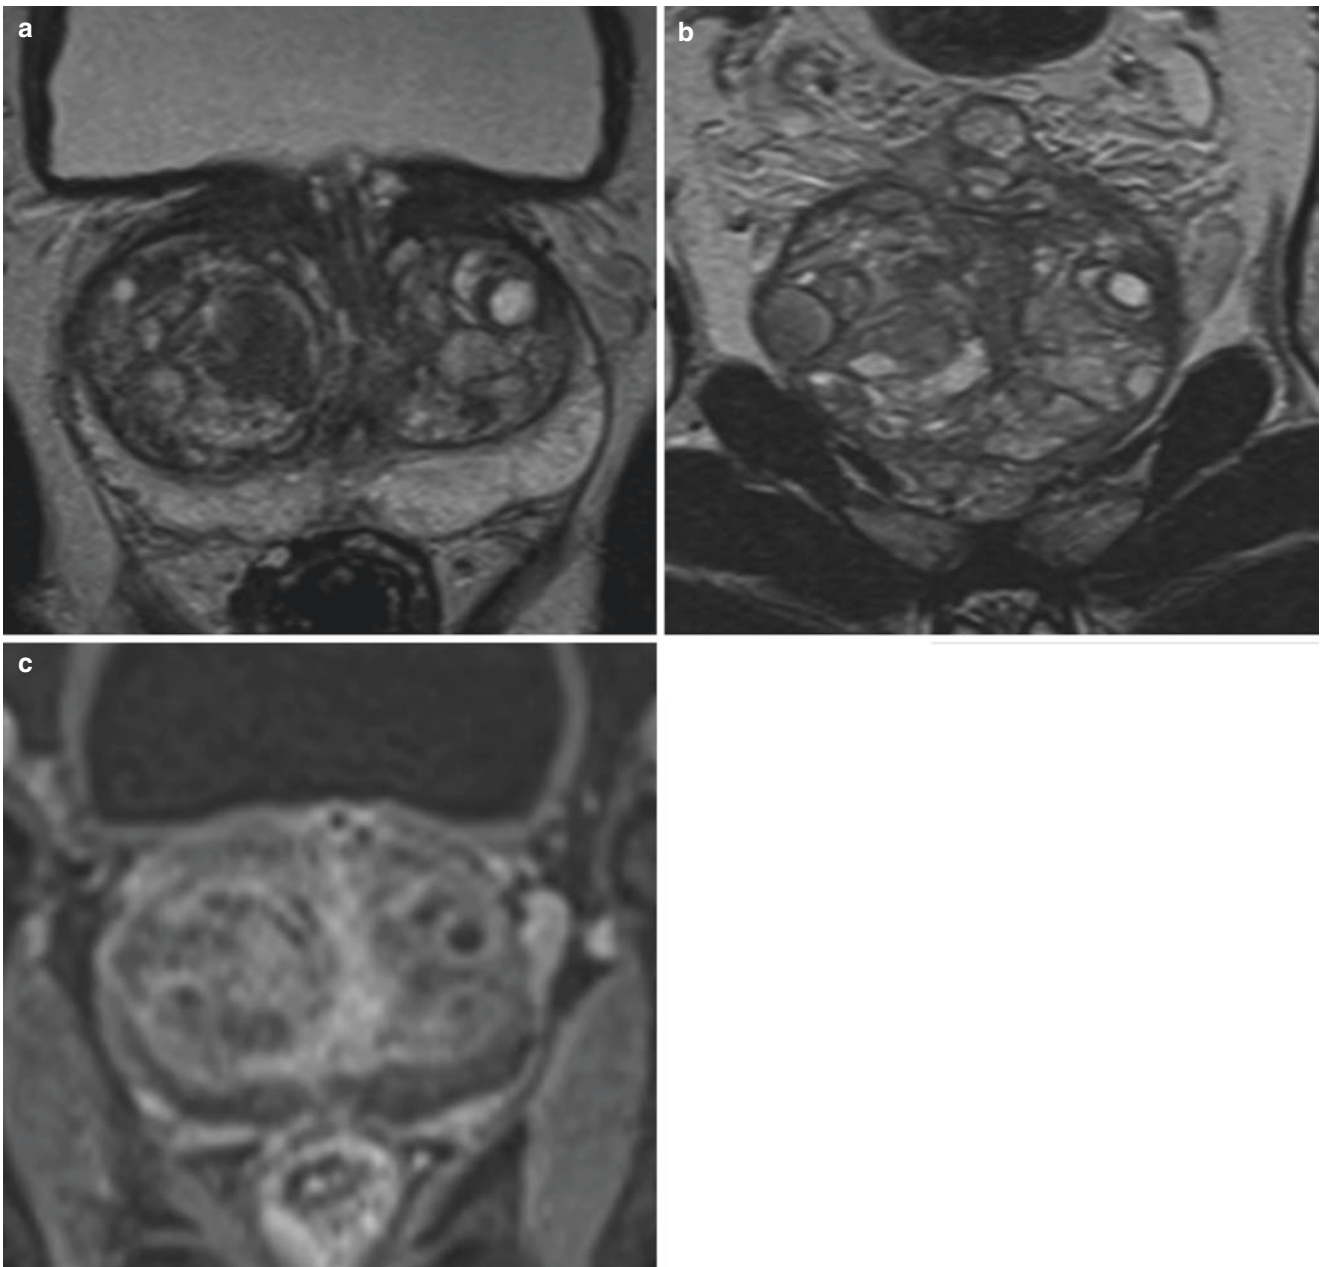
BPH in a 32-year-old man with lower urinary tract symptoms. Axial (a), coronal (b) T2-weighted MR images and axial (c) contrast-enhanced fat-suppressed T1-weight MR image show enlarged transitional zone with heterogeneous signal intensity, compatible with BPH
